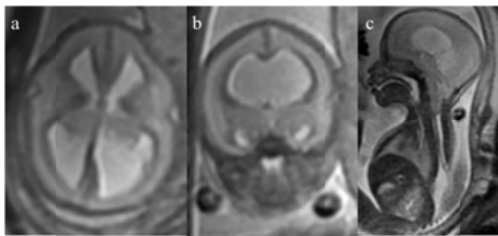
A case of complete agreement between ultrasound, in utero MR imaging and outcome reference data. The fetus was recruited into the MERIDIAN study from ultrasonography on the basis of a Dandy-Walker malformation and ventriculomegaly and in utero MR imaging was performed at 21 weeks gestational age. There is severe hypoplasia of the cerebellar vermis and increased volume of the posterior fossa present on the sagittal and axial iuMR images (3a and 3b) in keeping with a Dandy-Walker malformation. Mild ventriculomegaly is demonstrated on the axial image at the level of the trigones of the lateral ventricles (3c).
